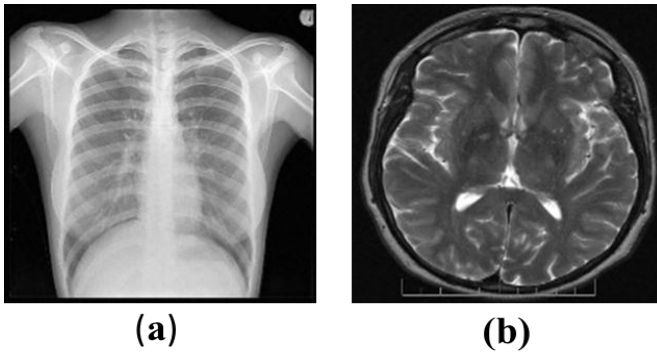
(a) Watermarked Chest X-Ray (b) Watermarked Human Skull Image
